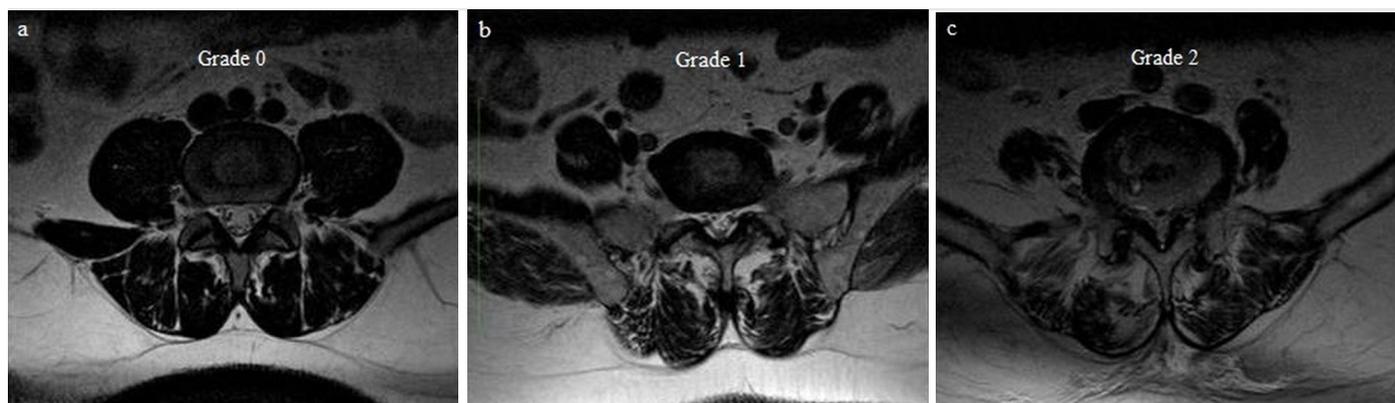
Axial T2-weighted images (WI) showing examples of LM muscle atrophy. Panel (a) shows grade 0 atrophy: fatty infiltration <10%; panel (b) shows grade 1 atrophy: fatty infiltration 10%-50%; and panel (c) shows grade 2 atrophy: fatty infiltration >50%
